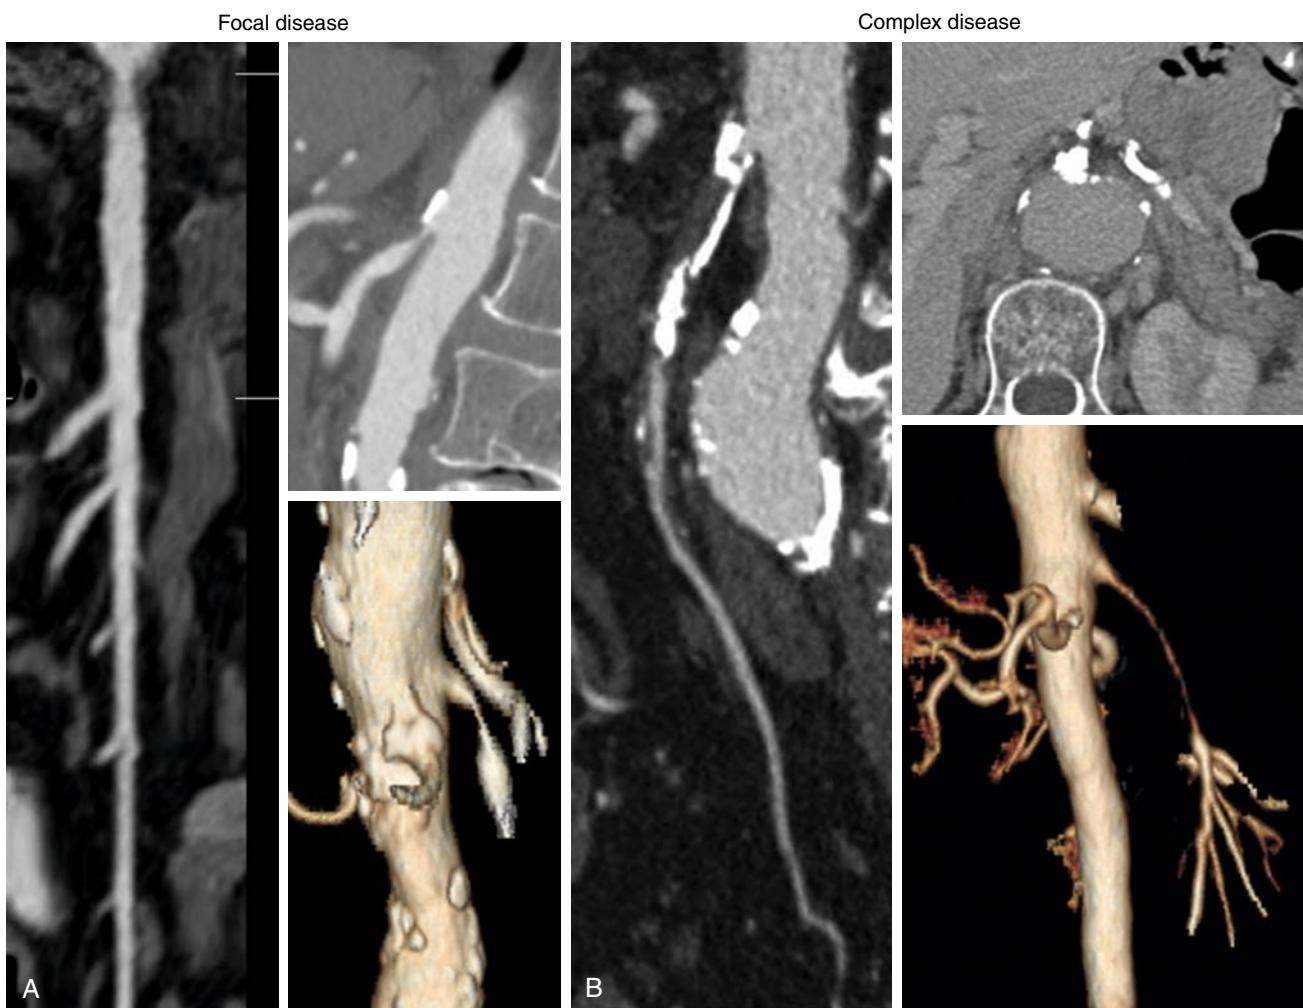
Computed tomography angiography is the most useful imaging study to plan revascularization. Anatomic characteristics of the superior mesenteric artery can be used to identify patients with focal disease where angioplasty and stenting is favored (A), or patients with complex disease where endovascular therapy is technically more challenging (B). Lesions with unfavorable anatomy for stenting include heavily calcified occlusions, long segment occlusions, and long segment stenosis involving multiple branches.
